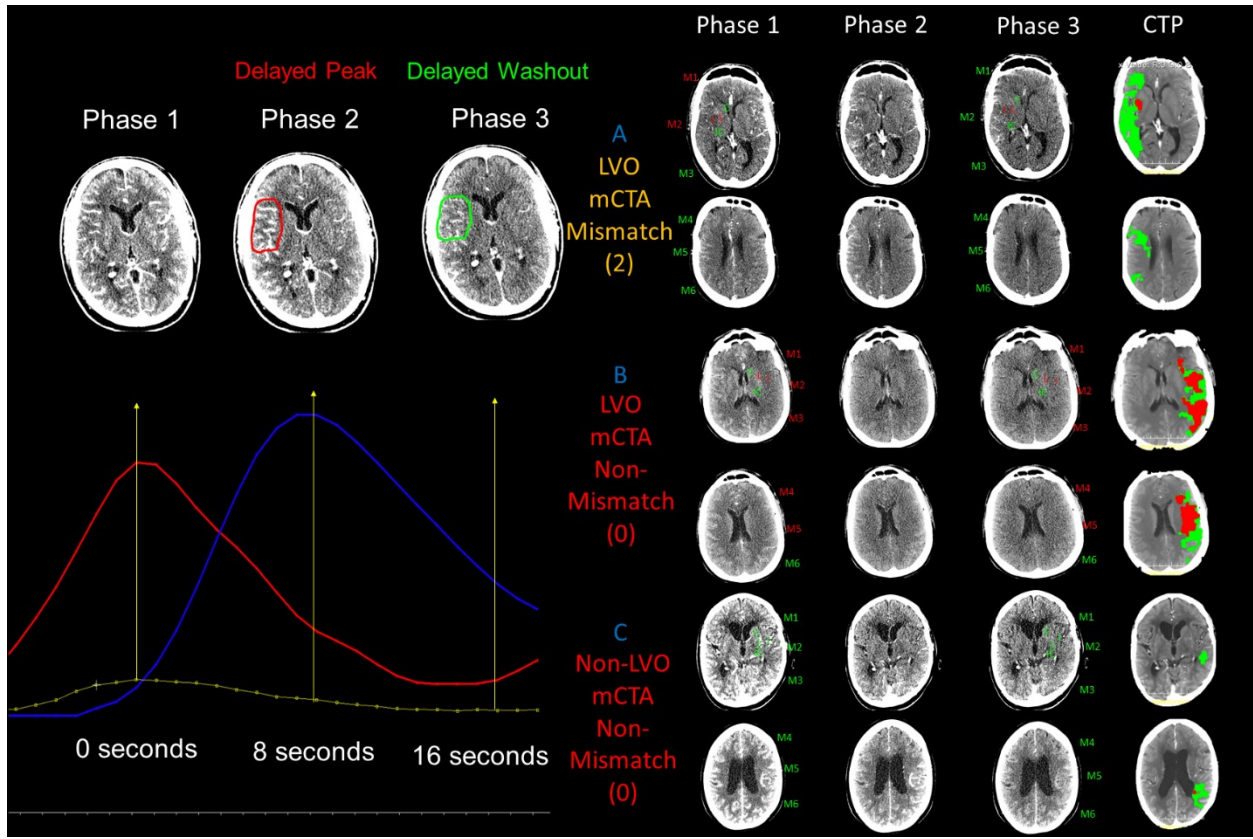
Multiphase CTA Images Derived from CT Perfusion Source Images. The peak arterial phase was defined as the first phase. The second and third phases were delayed by +8 and +16 seconds respectively. Images were scored regionally using the Alberta Stroke Program Early CT Score (ASPECTS). Affected regions are marked in red and unaffected regions in green. In the mismatch Large Vessel Occlusion (LVO) patient (A), the ASPECT score on phase 1 was scored 6 (lack of contrast opacification in M1, M2, lentiform, and insula). The ASPECT score improved on phase 3 to 8 (M1, M2 now opacified), and the mCTA mismatch score was 2. This was associated with a penumbral pattern on CTP (core = 3.6 mL, penumbra = 37.0 mL, mismatch ratio = 11.4). In the non-mismatch LVO patient (B), the ASPECT score on phase 1 was scored 3 (lack of contrast opacification in M1-M5, lentiform, and insula). The ASPECT score did not change on phase 3, remaining a 3, giving a mismatch of 0. This, however, was still associated with a penumbral pattern on CTP (core = 42.7 mL, penumbra = 33.6 mL, mismatch ratio = 1.8). In the non-mismatch non-LVO patient (C), the ASPECT score on phase 1 was scored 10 due to a lack of delay in peak filling of contrast. The ASPECT score did not change on phase 3, remaining a 10, giving a mismatch score of 0. This was also associated with a penumbral pattern on CTP (core = 0.1 mL, penumbra = 17.0 mL, mismatch ratio = 144.4).
